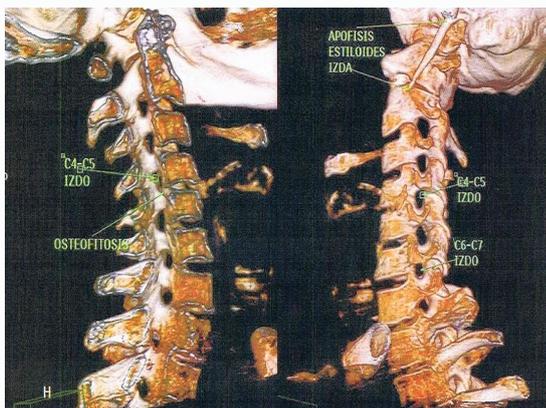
CBCT-3D. Elongated styloid process.
